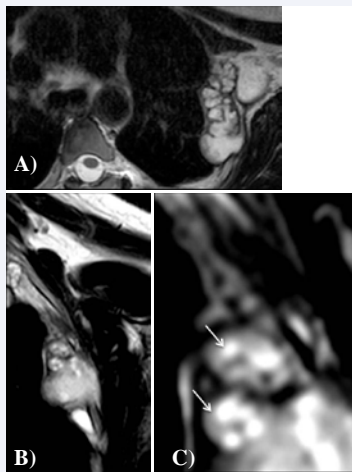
MRI, axial (a) and coronal (b and c) T2weighted images showing multivesicular hydatidosis with miniscule hydatid daughters (arrows).
